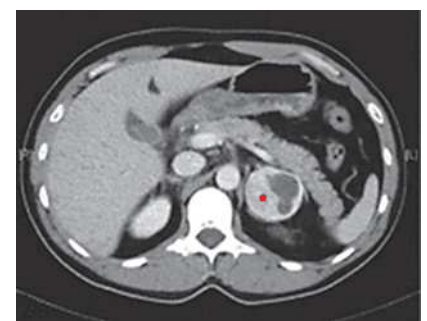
Pheochromocytoma. Abdominal CT shows a left adrenal mass of 50 mm in diameter with rounded, well-defined edges, and hyperdense areas of cystic necrosis inside (*asterisk*). (Reproduced from Martinez-Quintana E et al. *Int J Endocrinol Metab.* 2013;11(1):48-51.)
